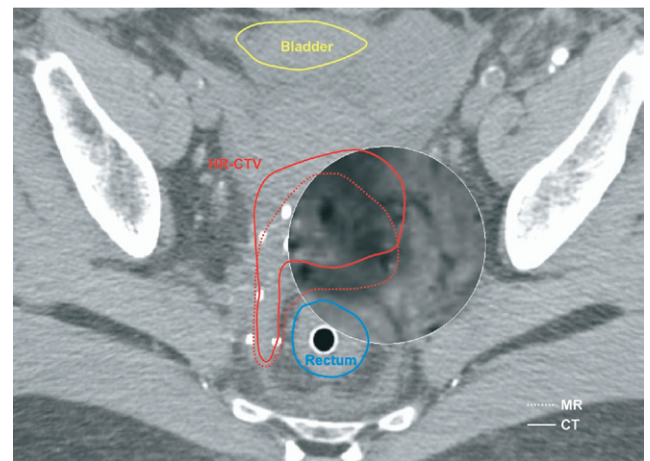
Axial computed tomography slice at level of uterine cervix of patient with Fédération Internationale de Gynécologie et d'Obstétrique Stage IIIB cervical cancer. High-risk clinical target volume extends into right uterosacral ligament (solid line indicates computed tomography contour; dotted line indicates magnetic resonance imaging contour). For bilateral parametrial coverage of high-risk clinical target volume, combined intracavitary/interstitial approach used. Spyglass viewing revealed underlying magnetic resonance image. On magnetic resonance imaging, low-signal-intensity cervical stroma can be easily differentiated from surrounding tissues, facilitating contouring of cervix. On computed tomography, borders of homogeneous mass, including cervix and parts of surrounding tissues, could not be distinguished, resulting in insignificant differences in delineation of right dorsal parametria.
